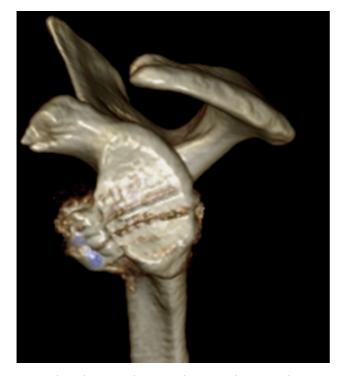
Three-dimensional computed tomography scan in the immediate postoperative period showing a well-positioned graft.
